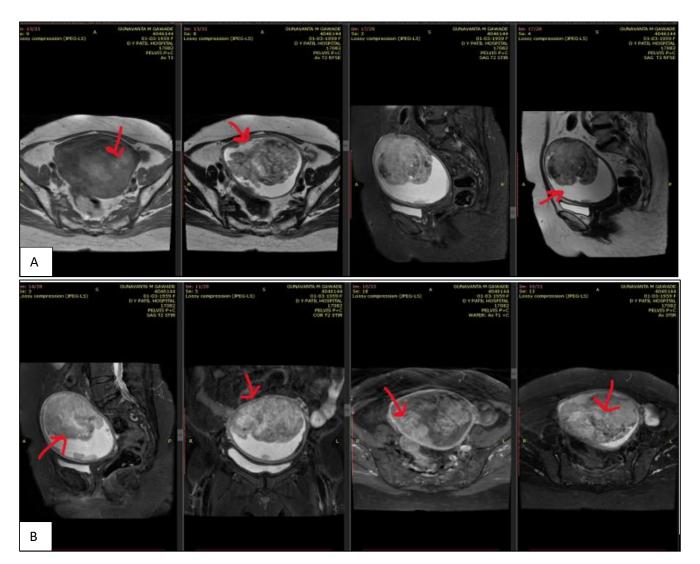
(A and B): A-showing MRI pelvis. B-showing MRI pelvis showing morphological changes.
